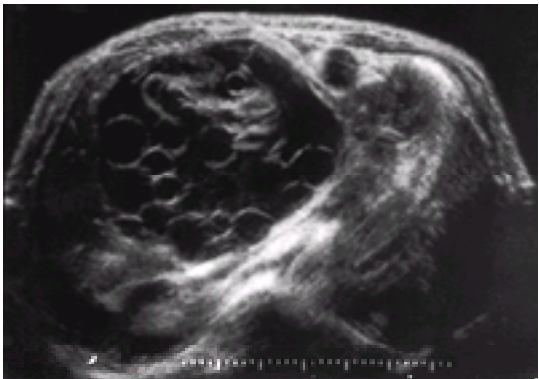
Ultrasonic image of *E. granulosus* in the liver, showing many daughter cysts within the main cyst.
